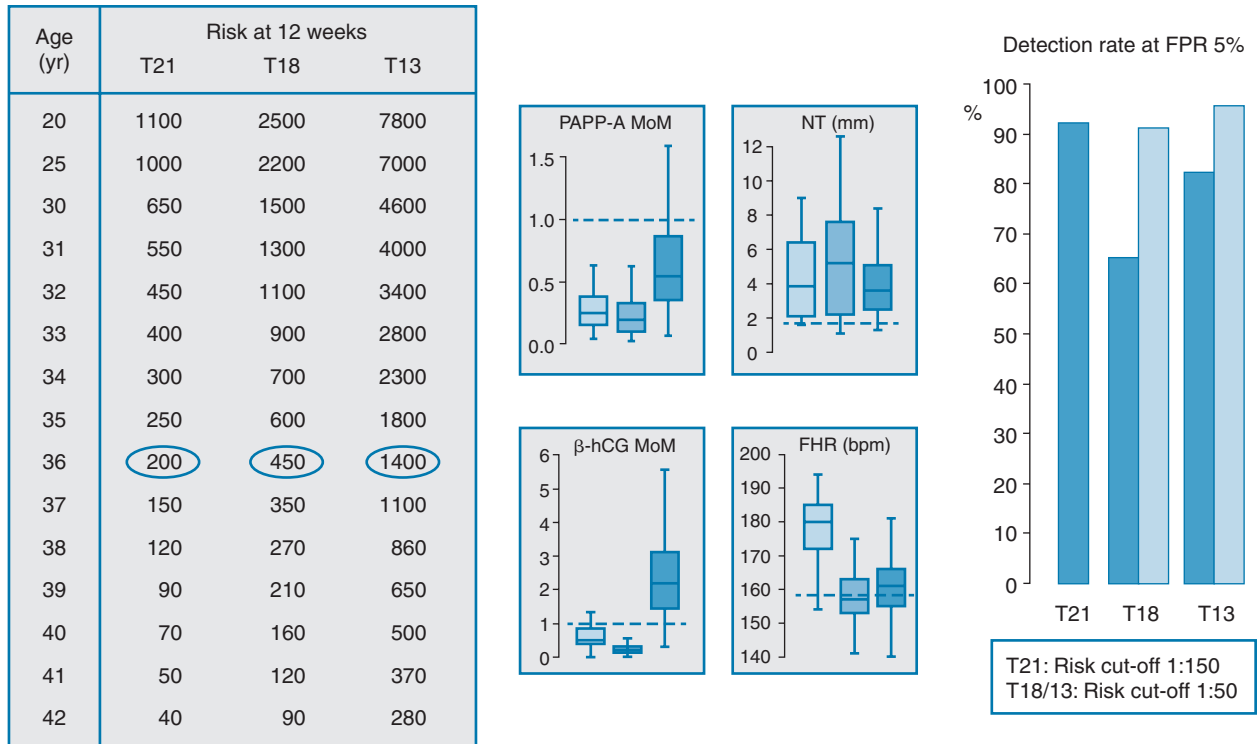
The risk of trisomy 21 (T21), 18 (T18) and 13 (T13) according to maternal age, nuchal translucency (NT), fetal heart rate (FHR), beta-hCG and pregnancy associated plasma protein A (PAPP-A). The detection rate (DR) and false positive rate (FPR) of 5% for each of these three aneuploidies using the combination of these markers are shown. (Adapted from Snijders RJ, Sundberg K, Holzgreve W, Henry G, Nicolaides K. Maternal age- and gestation-specific risk for trisomy 21. Ultrasound Obstet Gynecol 1999;13:167-170.)
